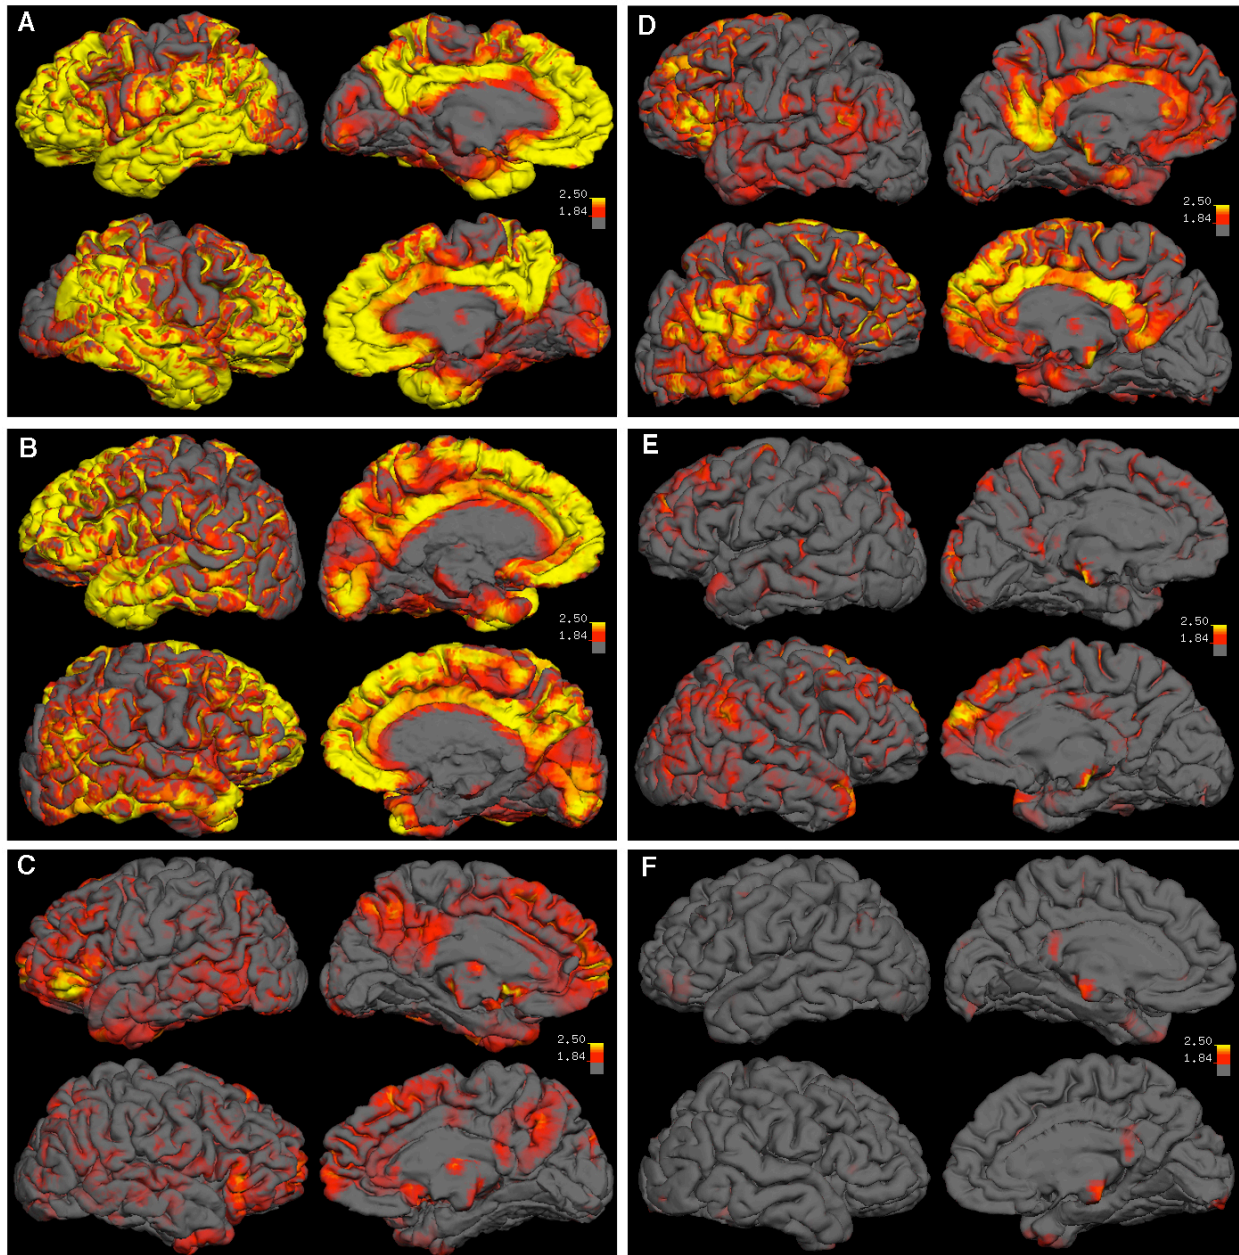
Partial volume corrected PIB-DVR images were overlaid on native space reconstructed surfaces derived from the subject's T1-weighted structural scan for 3 UCSF AD subjects (A-C) and 3 BAC NC subjects (D-F). Each box shows lateral and medial views of PIB distribution for a single subject (left hemisphere is above right hemisphere in each box). All images reflect the same color scale, with yellow indicating high PIB uptake, red indicating medium PIB uptake, and gray indicating low PIB uptake.
